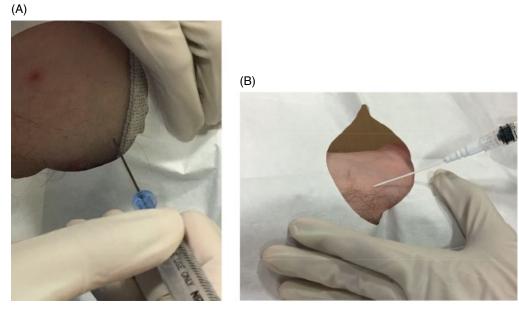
Introducer needle angles for arterial catheter insertion. (A) Axillary line cannulation with needle positioning shown at a steeper angle (70-80°). This steeper angle is used to improve visualization of the needle tip under ultrasound (not shown) in the larger axillary or femoral vessels. (B) Radial line cannulation with needle positioning shown at a more shallow angle (e.g. 45° or less) to avoid penetrating the posterior wall of this small artery.
